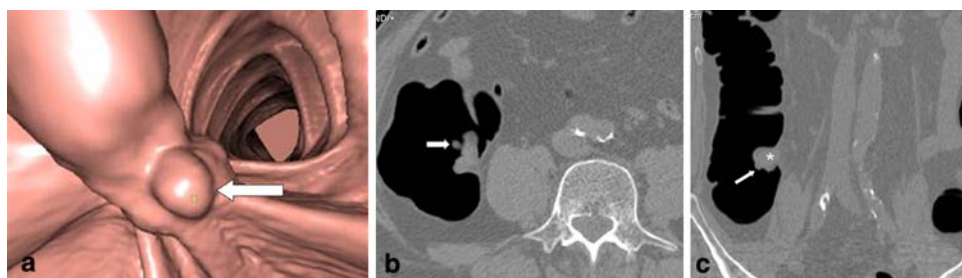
72-year-old woman with adenocarcinoma of ileocecal valve. A Three dimensional threshold-rendered endoluminal CT colonograph of ascending colon shows an ileocecal valve characterized by irregular surface (*arrow*). B Axial CT scan using abdominal window at same level as A
